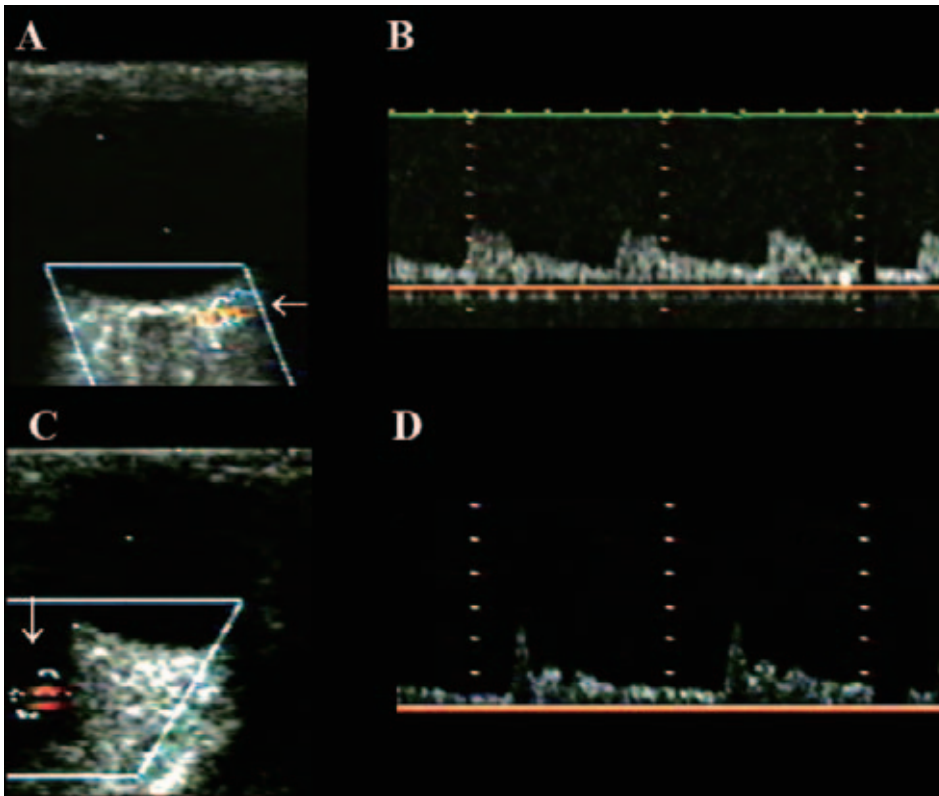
Color pulse Doppler sonography of the CRA and the OA in a healthy volunteer. Color visualization with color Doppler ultrasonography on a B-mode background is shown on the left (A, B), and spectral waveform with pulsed Doppler is shown on the right (C, D). (arrow: sampling position)
